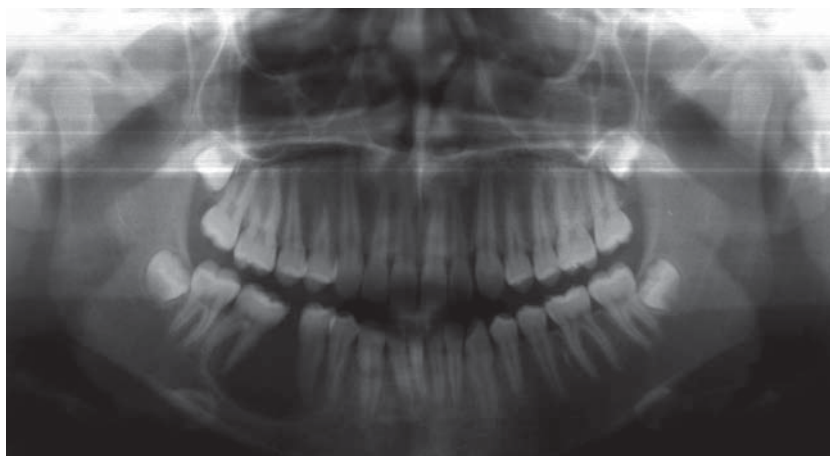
Panoramic radiograph showing large unilocular radiolucent area three years after initial diagnosis
